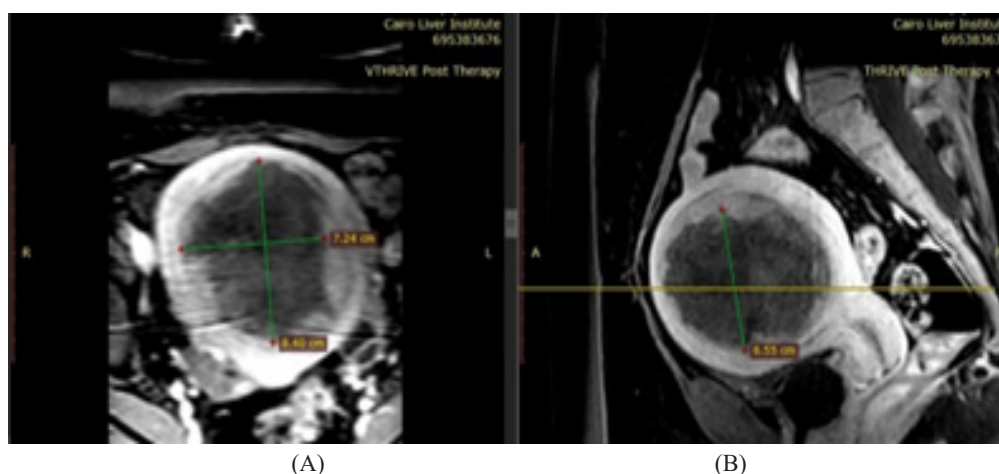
Post MR-HIFU for patient in figure 1. (A) Axial & (B) Sagittal post-contrast T1 MRI images revealed areas of non-enhancement within the former myoma denoting well ablation. Volume of ablated areas after HIFU = 200 cc, calculated NPV = 65%.
